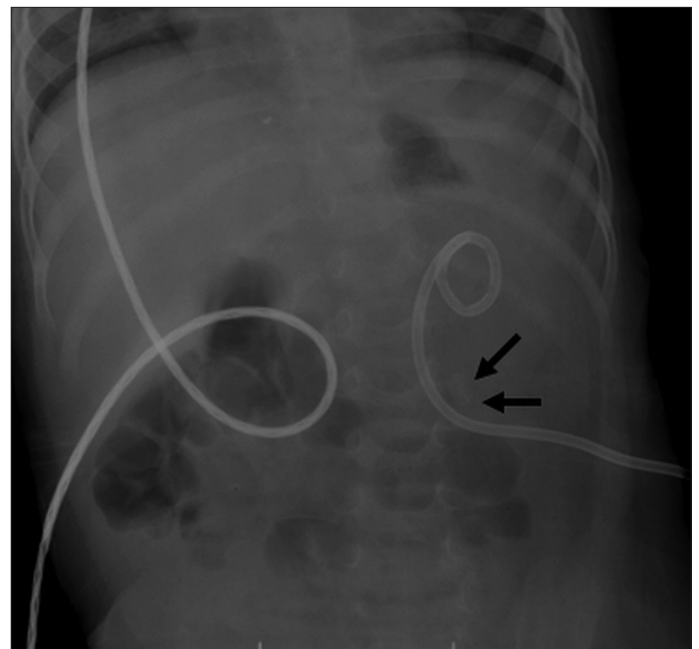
[Plain roentgenogram]. Arrow shows radio-opacity consistent with the presence of urinary stone
